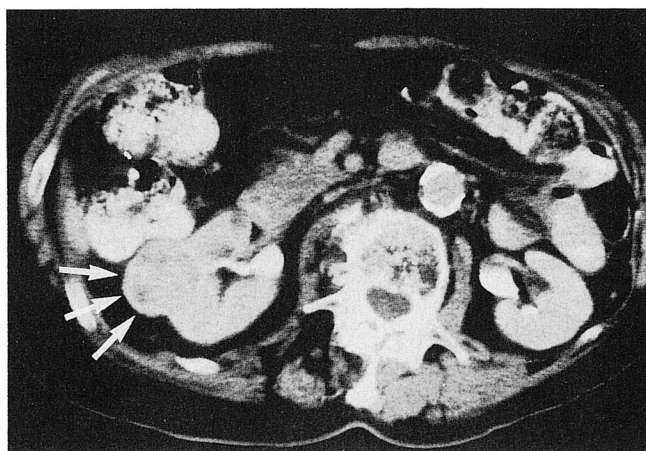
Preoperative CT scan reveals 3 cm. renal mass (arrows) occupying lateral border of mid portion of right kidney. Right kidney measures 6.5 × 8.5 × 6.5 cm.
